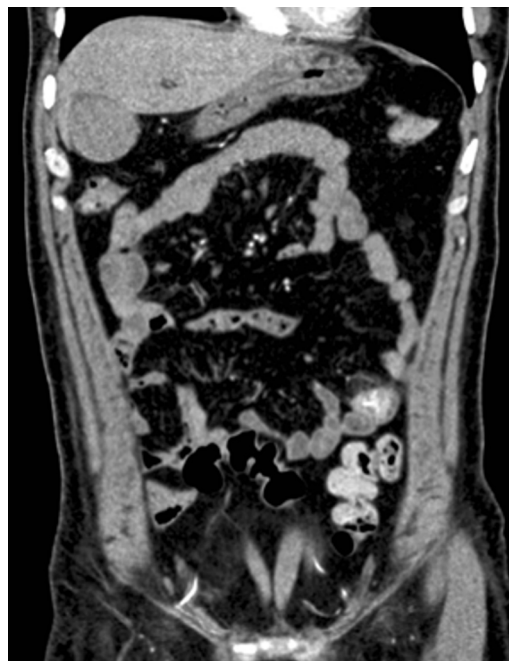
Coronal section of CT abdomen showing hypervascular lesion in ileum.
